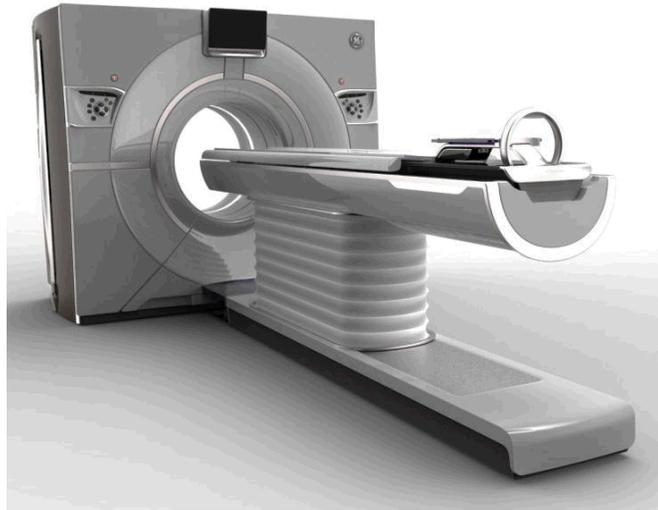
The new GE Discovery CT870 HD scanner, known internally as the Revolution CT scanner.
